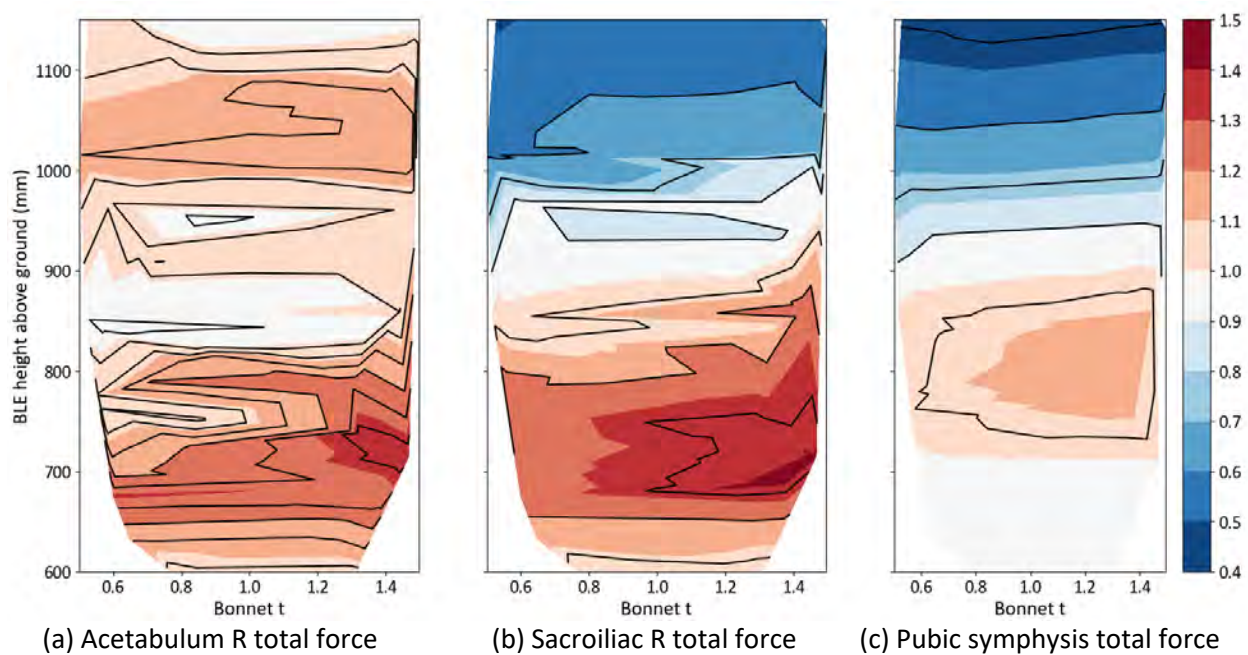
Normalised maximum HBM pelvis injury values for the non-struck side (right pelvis of the HBM) at test position Y0 for the SUV by varying the exterior sheet thickness of the bonnet and the shooting height of the HBM (converted to BLE height above ground).
